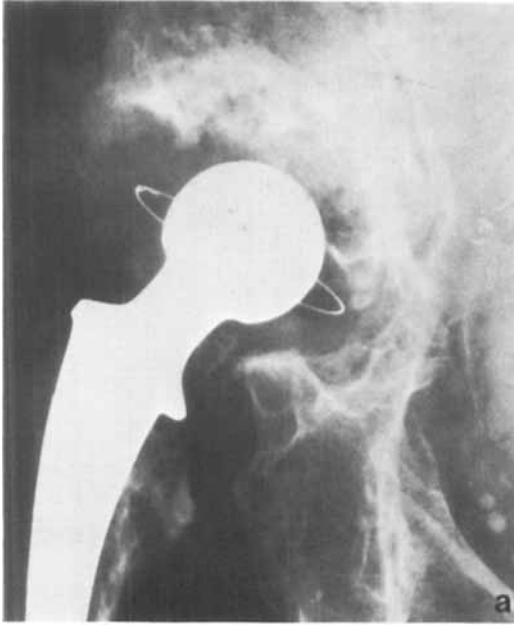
(Case 3). a. Plain radiograph of the right hip shows destructive changes and osteopenia involving the acetabulum. Note difficulty in establishing the completeness of the acetabular fossa. b. CT scan demonstrating minimal amount of bone stock at the proposed site for a revision arthroplasty. In spite of linear computer artifact, created by the metallic prosthesis, the required diagnostic information is obtained.
